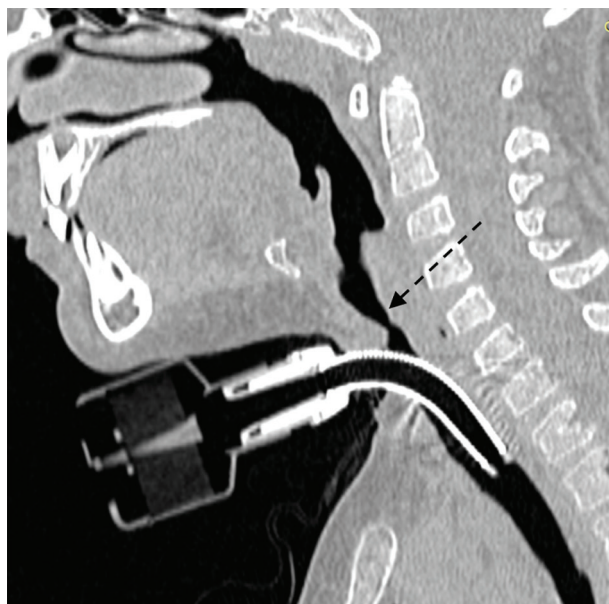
Violation of the cartilaginous framework of the larynx and trachea revealed by CT
